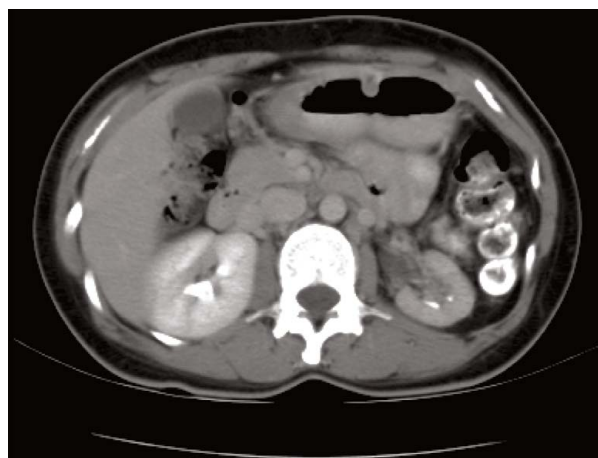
Computed tomography scan at 1-year follow-up, showing mildly dilated left renal pelvis.
